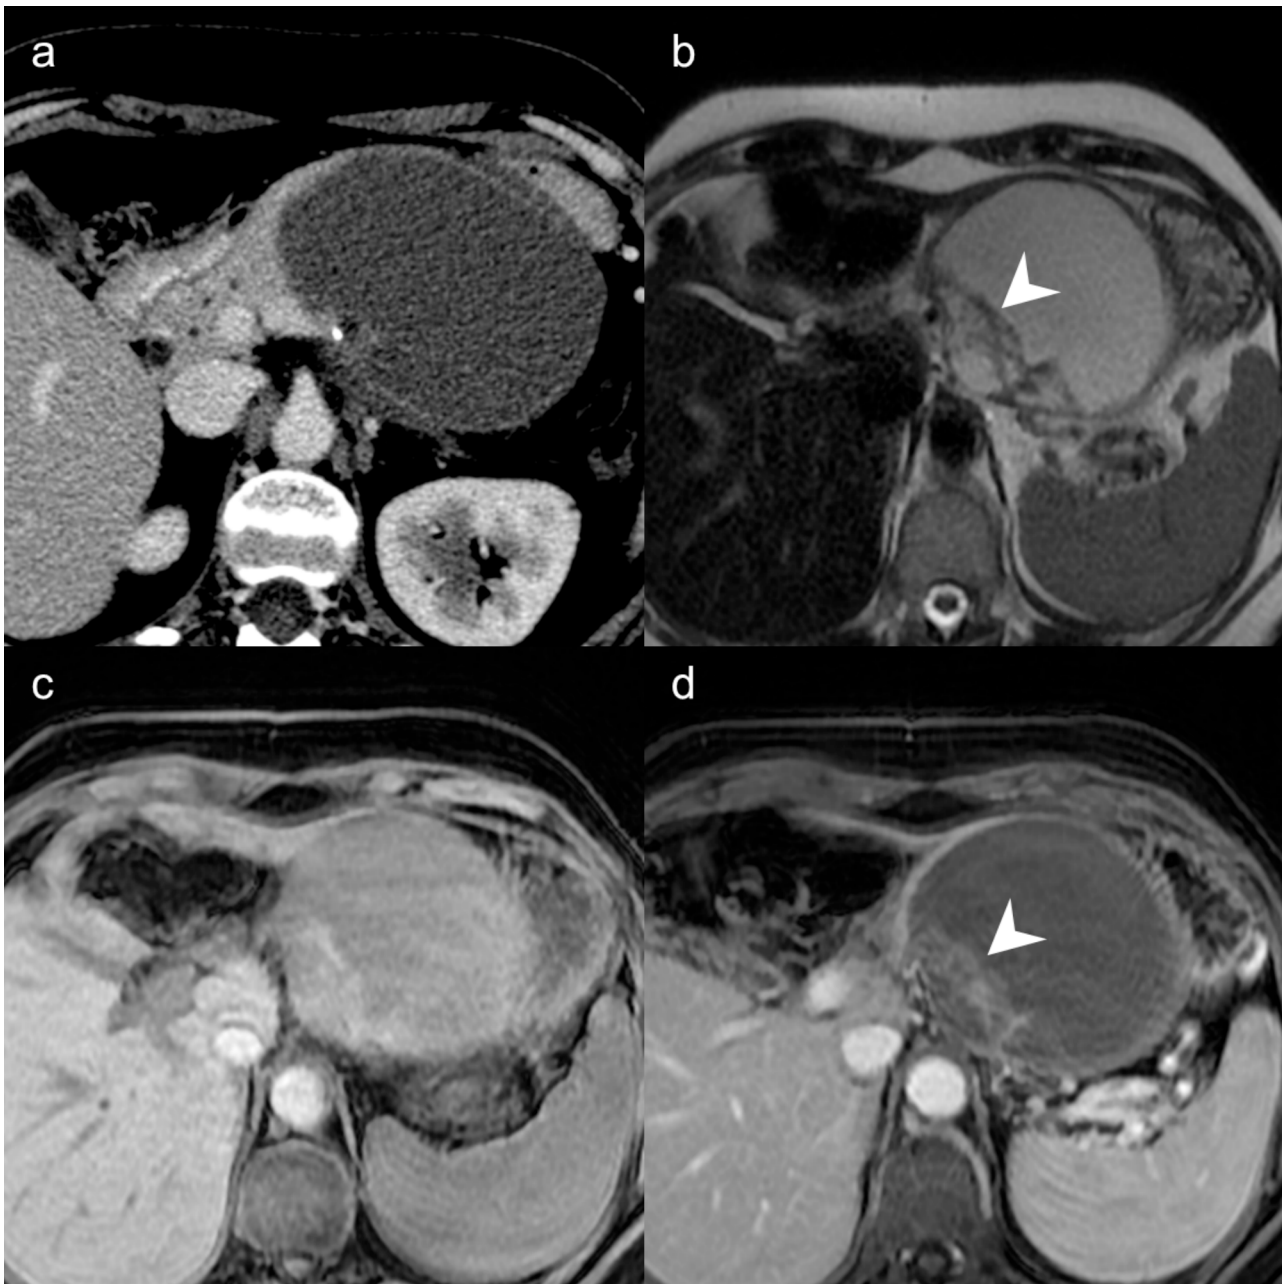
59-year-old female with malignant degeneration of mucinous cystic neoplasm. Contrast-enhanced CT (a) shows a large cystic lesion in the pancreatic body and tail with peripheral calcification. On MRI, the lesion demonstrates T2 hyperintensity with internal septa (b, arrowhead), iso-to-hyperintense T1 signal (c), and septa enhancement on post-contrast venous phase (d, arrowhead).
